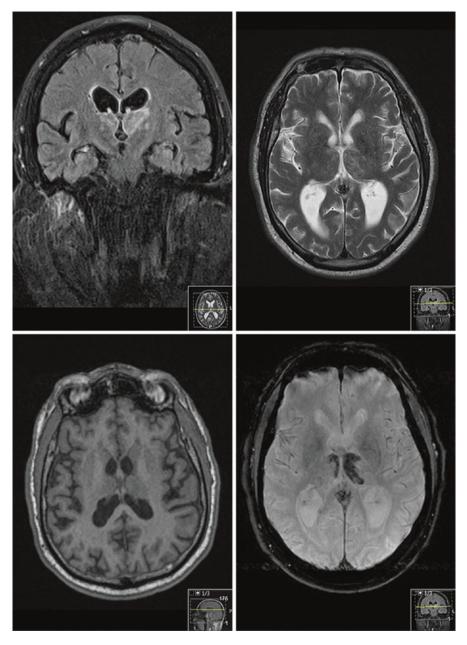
MRI of the bithamalic lesions. *Top row left:* coronary FLAIR, hyperintense signal predominantly in the left thalamus. *Top row right:* axial T2-hyperintense signal. *Bottom row left:* axial T1-iso-/hypointense signal. *Bottom row right:* T2*-hypointense signal
